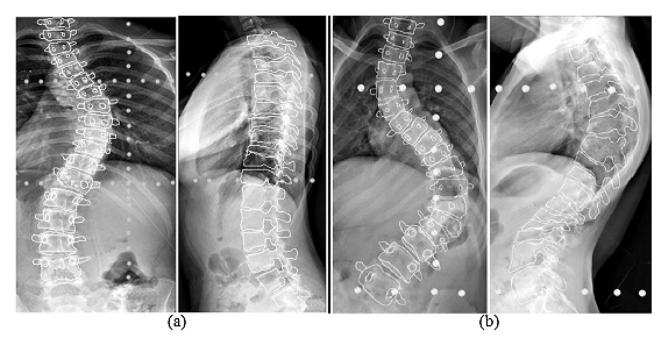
Qualitative validation by retro-projecting CSCPG model on two views of the bi-planar X-rays (a) subject-1(b) subject-2.
